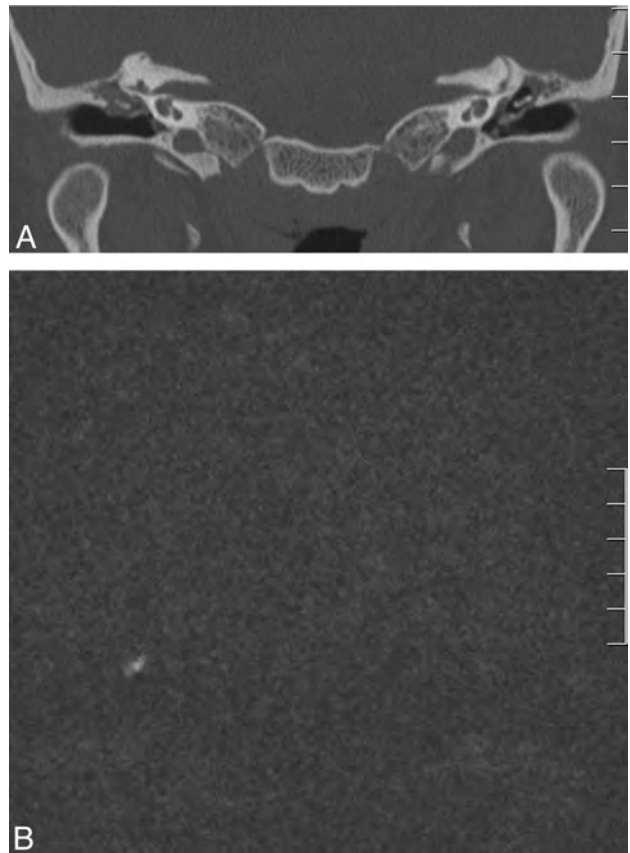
Case 5. A 29-year-old man with a history of chronic bilateral otitis media with effusion with a tympanic ventilation T-tube on the left side. A, Coronal CT scan shows bilateral tympanic thickening and middle ear opacities, with erosion of the scutum; a T-tube can be observed on the left side. B, Coronal HASTE shows a 13-mm right-sided hyperintensity in relation to the epitympanum. The cholesteatoma was found intraoperatively (not shown).
